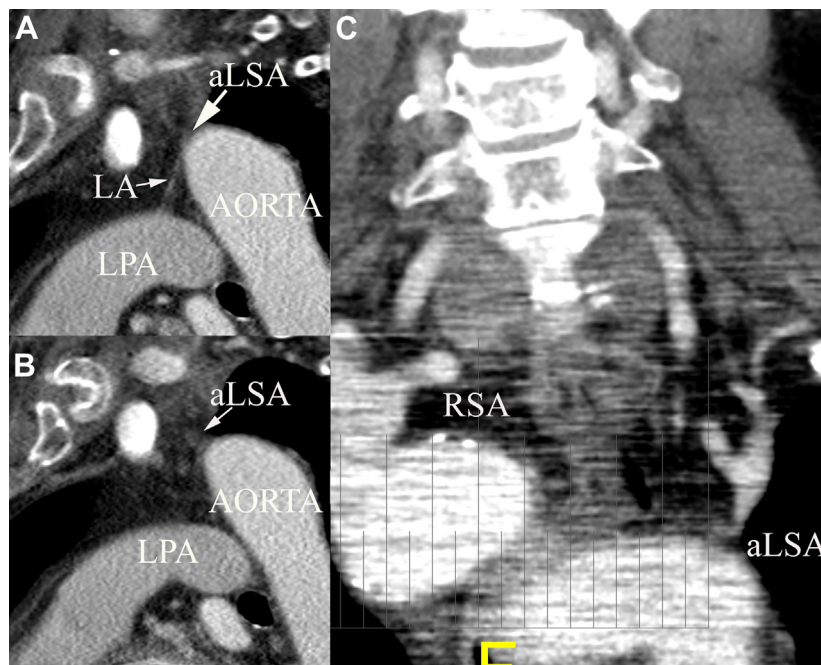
A, Computed tomography angiography showing a ligamentum arteriosum (LA) between the left pulmonary artery (LPA) and the origin of the aberrant left subclavian artery (aLSA). B, The origin of the aLSA from the descending aorta showed no pronounced diverticulum of Kommerell. C, Anteroposterior computed tomography reconstruction of the proximal aLSA with the ostium of the vertebral artery. The proximal segment of the right subclavian artery (RSA) is also visible.
